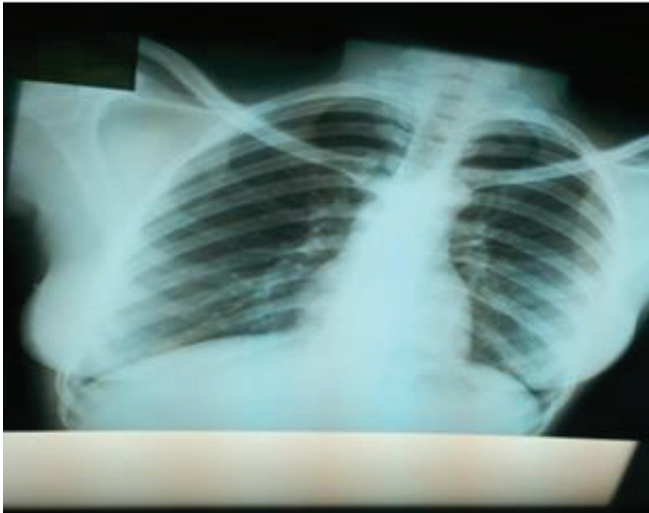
Case 2. Normal chest X-ray
